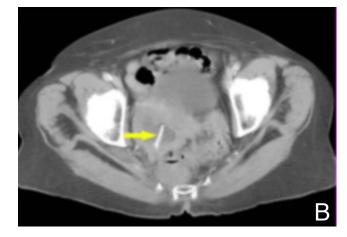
A and B. Axial enhanced CT images showing a mass with an enhancing, thick wall (arrows), with internal air, fluid, and a linear ossific density (arrowhead) suggesting bone.
